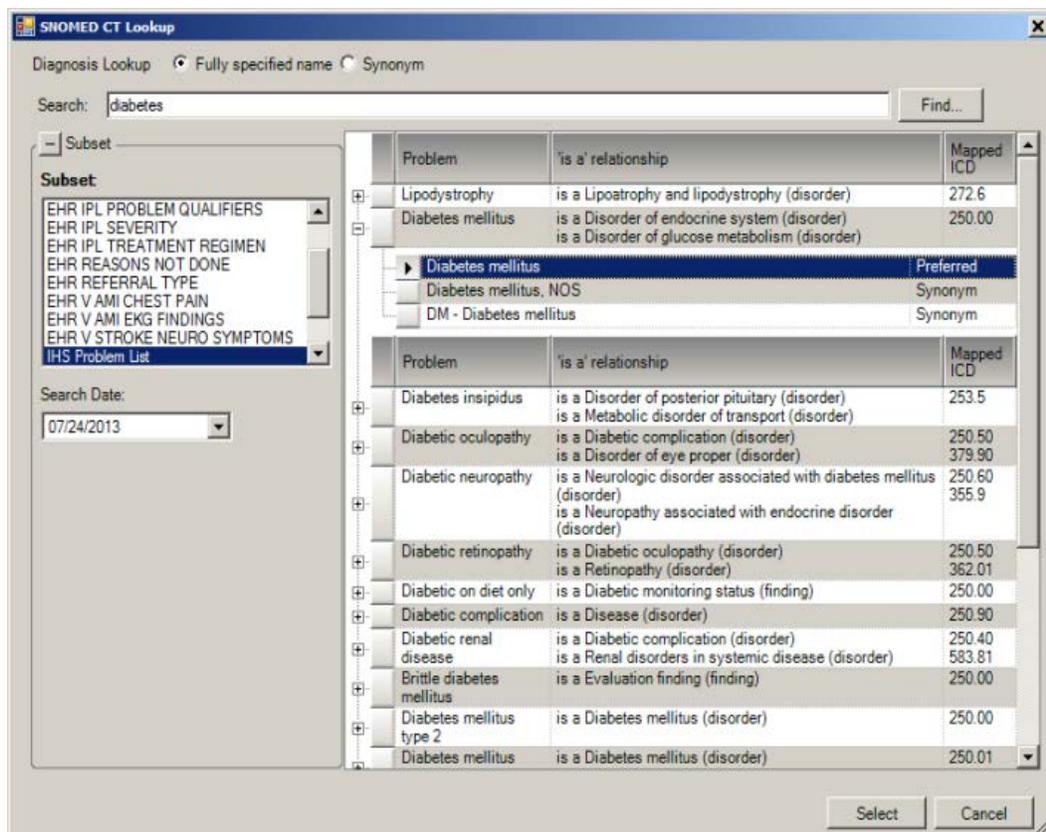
SNOMED CT Lookup dialog
